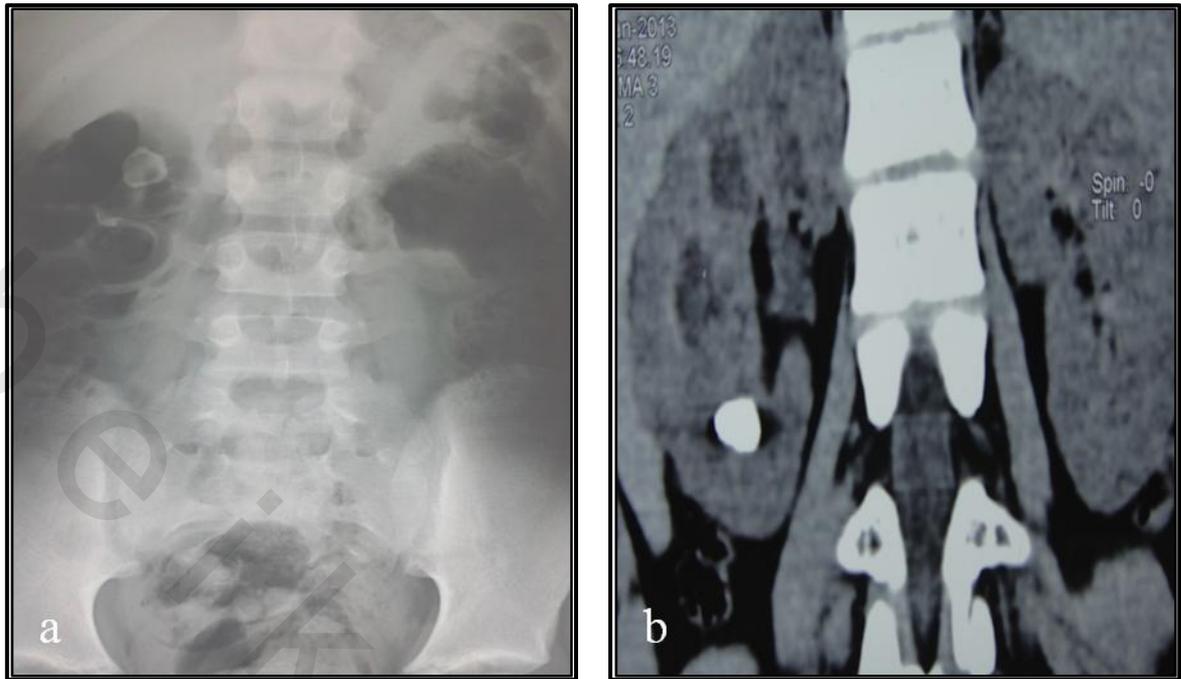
6 years female child (a) plain x ray showing radiopaque shadow in the right hypochondrium (b) multislice CT abdomen and pelvis showing lower calyceal stone.
